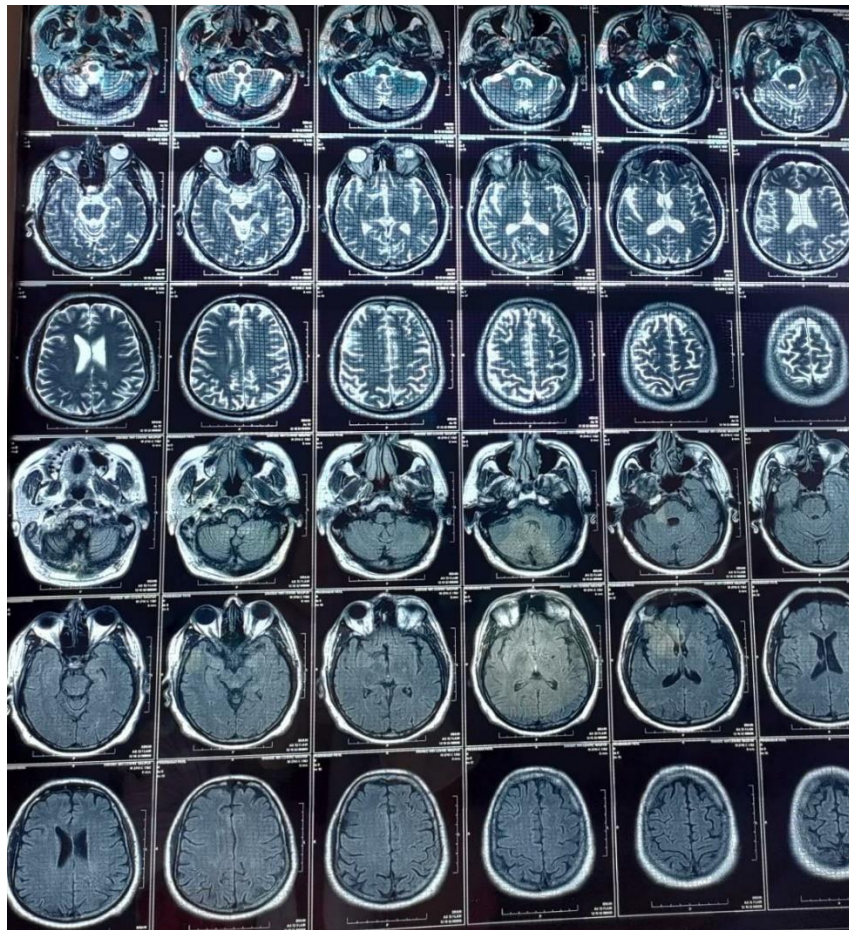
MRI of the brain.
